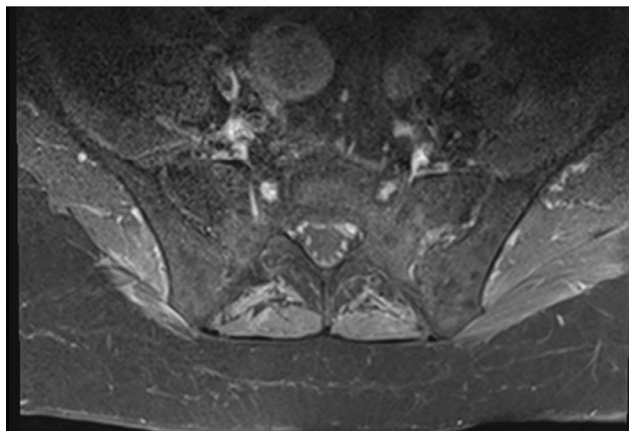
MRI lumbar spine, post gadolinium contrast. On the left is the initial MRI spine, demonstrating abnormal enhancement and uptake in the nerve roots. On the right is the MRI following baricitinib, with resolution of the abnormal uptake in the nerve roots.
